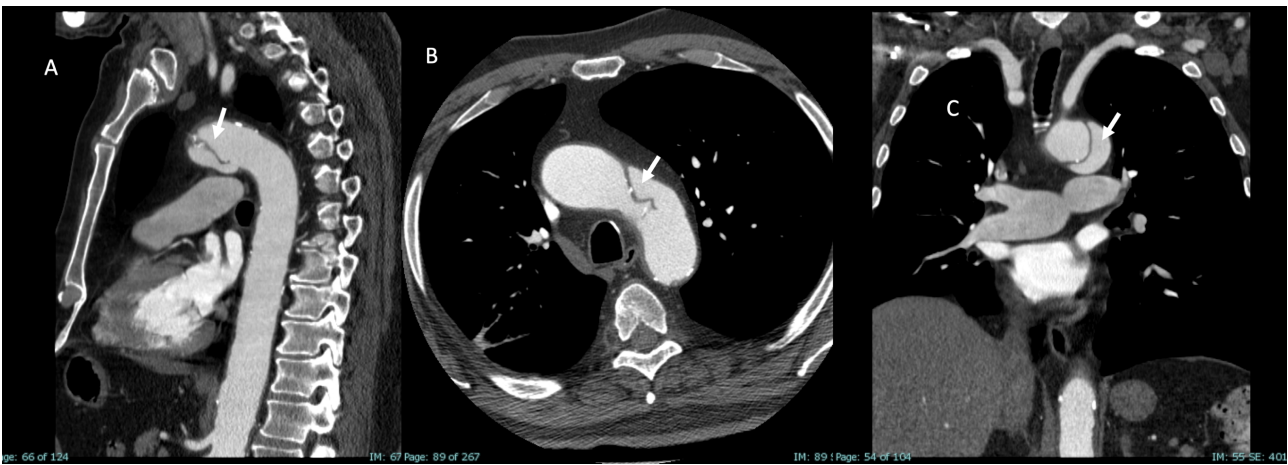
Angio-CT representation of the thoracic aorta showing (arrows) the dissection flap in the aortic arch in longitudinal (A-B) and transverse (C) projections.
